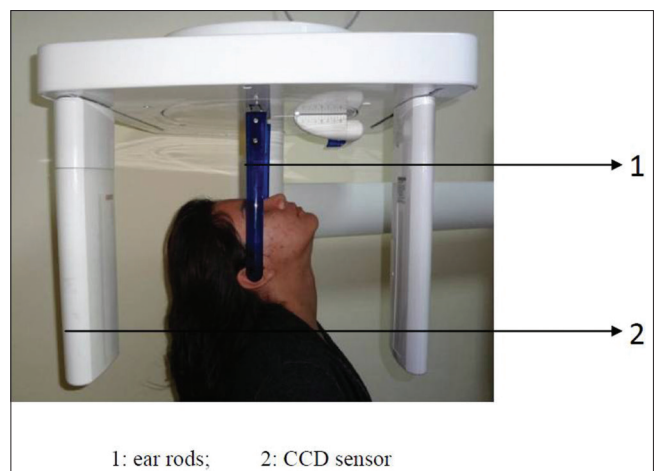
Patient positioned for digital submentovertex radiograph
